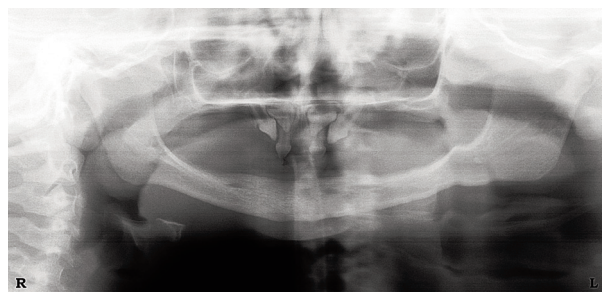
Orthopantomogram reveals severe hypodontia and undeveloped alveolar ridges: four deciduous teeth and two developing permanent teeth in the frontal region of the maxilla, and anodontia in mandible.
